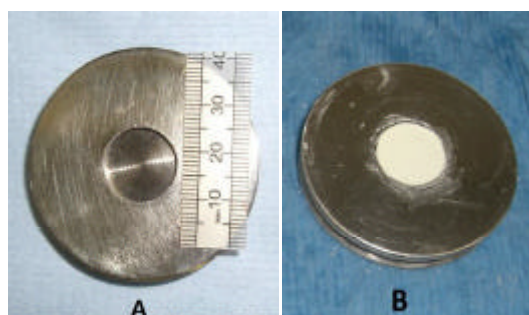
(A) An aluminium XRD sample holder (Panalytical, Almelo, Netherlands) with a round depression in the centre (20 mm diameter & 2 mm depth). (B) The depression of one sample holder was filled with MTA slurry using minimal pressure followed by the application of ultrasonic agitation.
